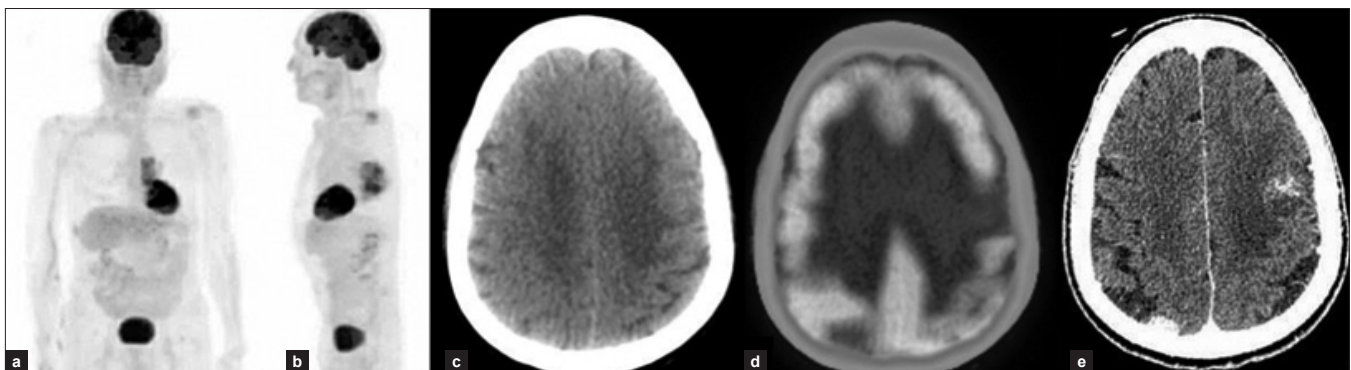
70-year male papillary adenocarcinoma of the right submandibular gland with bone mets on MRI; (a, b) Anterior and lateral MIP image showing hyper-metabolism in the left lung; (c, d) Axial LDCT and fused PET/CT demonstrate hypometabolism in the left high frontal lobe corresponding to an iso-dense lesion with surrounding edema on CT; (e) Axial CECT at the same level reveals a ring enhancing lesion with surrounding edema in left frontal region and another small homogeneously enhancing lesion in right parietal region
